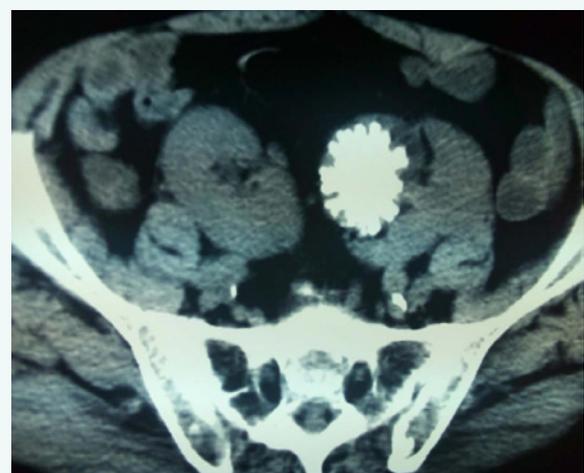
Bilateral pelvic kidney with calculus within left kidney seen on CT scan.
